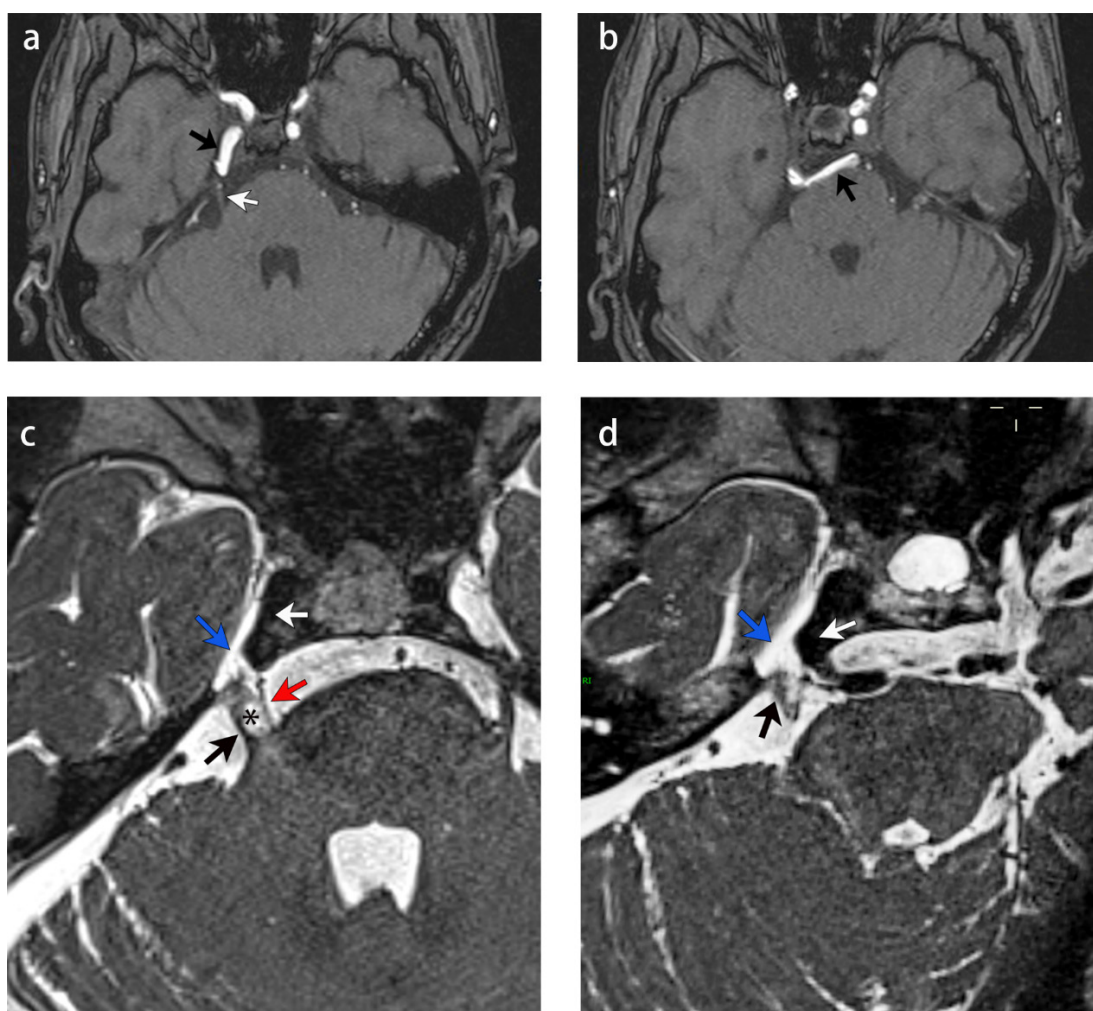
Axial TOF-3D sequence of MRI examination before MVD (a, b) and axial T2-SPACE sequence of MRI reexamination before PBC (c, d) PTA (black arrow) originates from the cavernous sinus segment of the right ICA and passes through the MC, compressing the right MC and part of the cistern trigeminal nerve (white arrow) (a). PTA turns anteromedially into the cistern at the entrance of the MC (b). A Teflon piece (asterisk) has separated the cistern trigeminal nerve (black arrow) from the small artery (red arrow) from PTA (c). The dilated PTA (white arrow) trunk in the MC (blue arrow) also compresses the trigeminal nerve (d).
